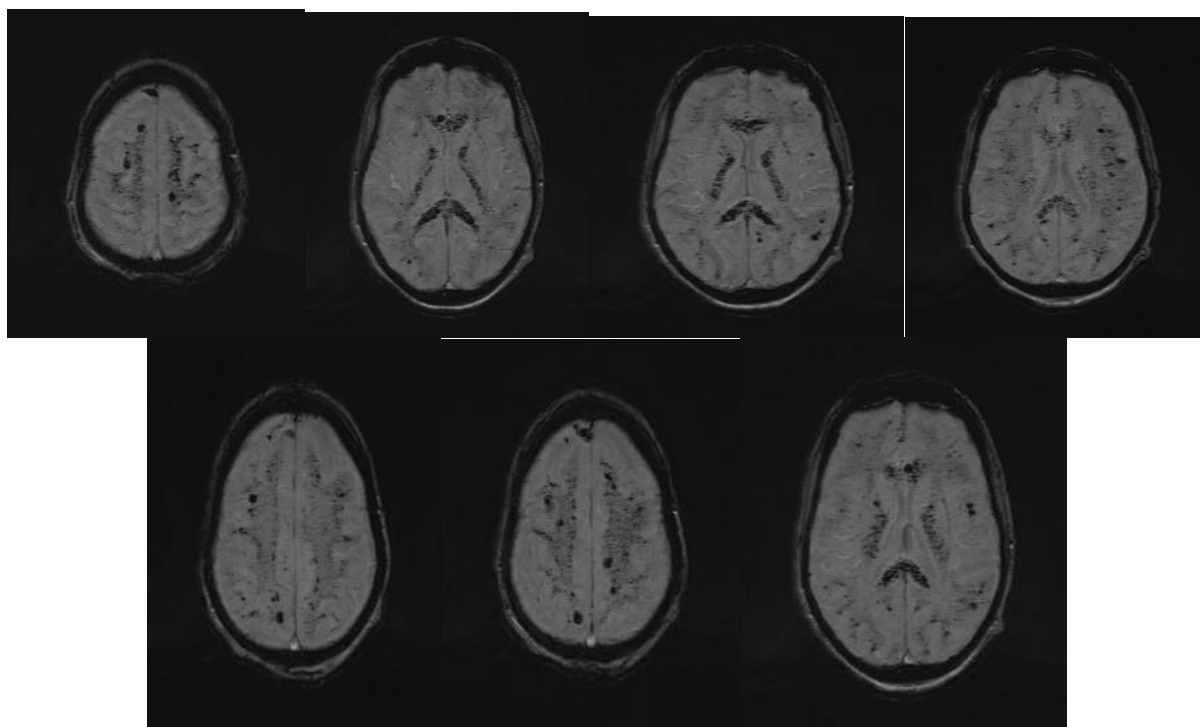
Susceptibility weighted MRI sequence images (SW - MRI) demonstrate extensive dots like microbleeds in bilateral cerebrum including corpus callosum.
